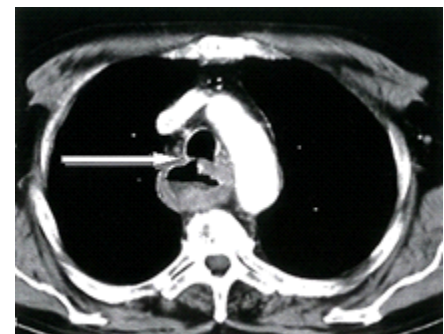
Surgery planning of esophageal cancer from PET-CT scan
